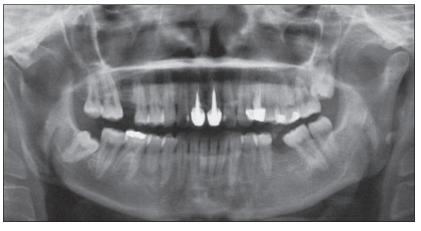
(right) Preoperative panoramic radiograph showed the residual bone height to be 5.4 mm.
